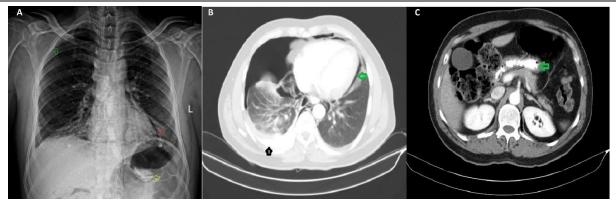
A: Chest X-ray showed right-side pneumothorax (green arrow), pneumomediastinum (red arrow) and foreign bodies in stomach (yellow arrow). B: Computed tomography scan exhibited gastrografin leak into the left pleural space (black arrow) and pneumomediastinum (green arrow). C: Note foreign bodies in the stomach (green arrow).
